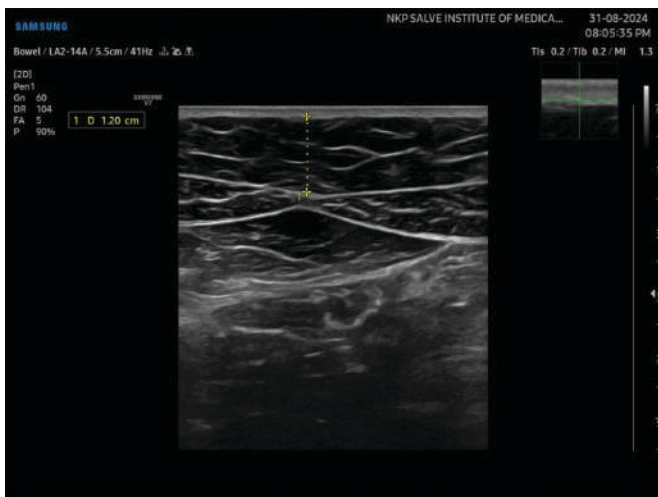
Image showing measurement of maternal subcutaneous fat thickness (mSFT) in the subxiphoid region, obtained as the distance from the skin surface to the rectus muscle, with the ultrasound probe placed perpendicular to the abdominal wall
